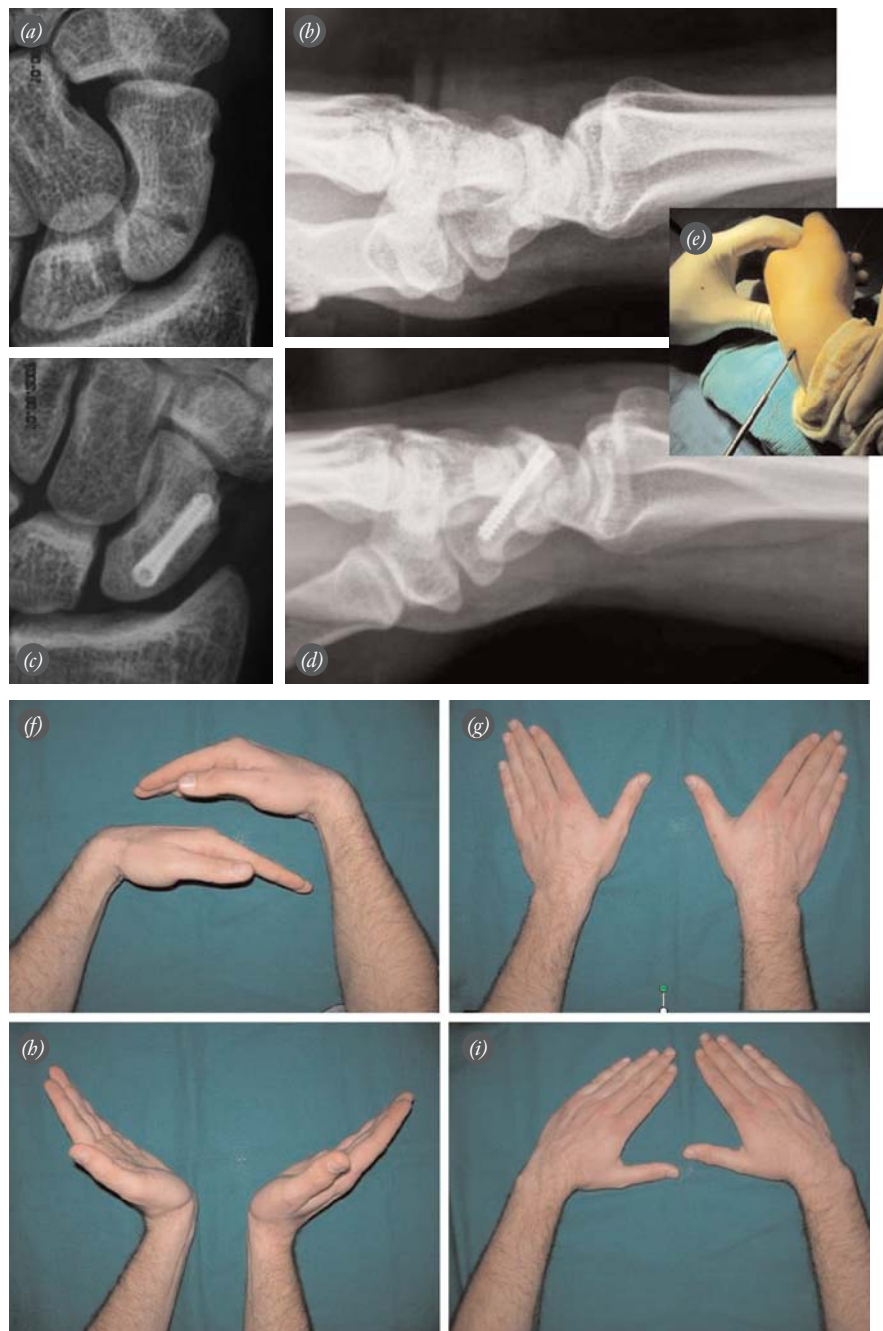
Images of the scaphoid fracture of a 25-year-old patient. (a) Preoperative anteroposterior, (b) preoperative lateral, (c) postoperative anteroposterior, and (d) postoperative lateral X-rays are seen. (e) Screw placement in the dorsal approach. (f-i) Postoperative 47th month clinical views of the patient. The patient's PRWE score was 1 and Mayo score 90. [Color figure can be viewed in the online issue, which is available at www.aott.org.tr]
